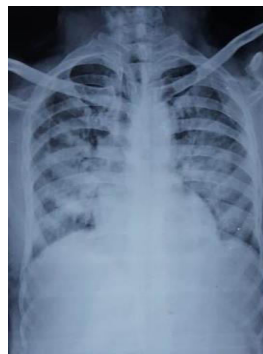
Figure VI (b): X-ray picture showing batwing appearance, suggestive of pulmonary oedema
